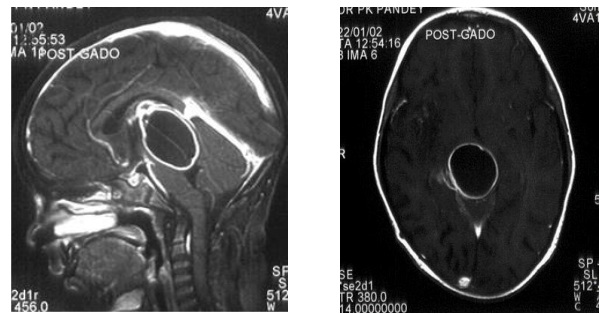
Pre-operative sagittal & axial T1 contrast MR images of tubercular abscess.
